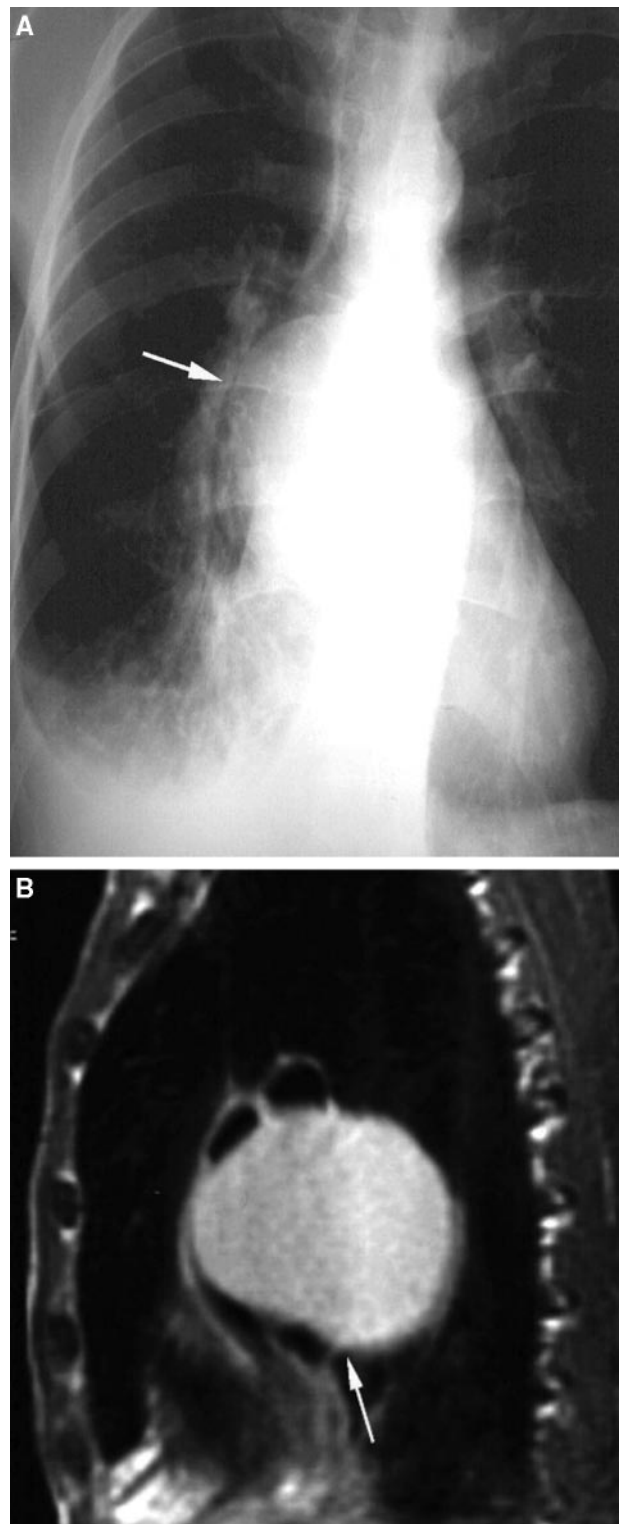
Top, A:* a 49-year-old man with a bronchogenic cyst. A chest radiograph shows a rounded mass (arrow) that displaces the right primary bronchus superiorly. *Bottom, B:* a 49-year-old man with a bronchogenic cyst. A sagittal T1-weighted magnetic resonance image shows a high-signal intensity cyst with a fluid-fluid level due to infection (arrow).
